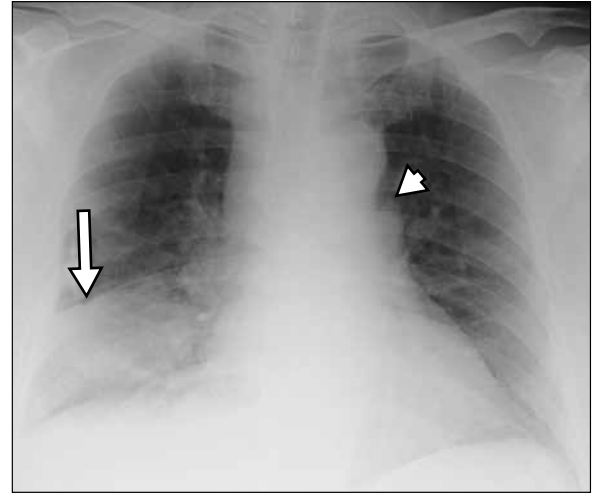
Chest radiograph of a 61-year-old man, a known smoker, who presented with right-sided chest pain for a day. Right lower zone pleural-based opacity, representing a Hampton's hump (arrow), is seen. Prominent main pulmonary artery is seen as convexity of the pulmonary bay, typical of Fleischner's sign (arrowhead).
